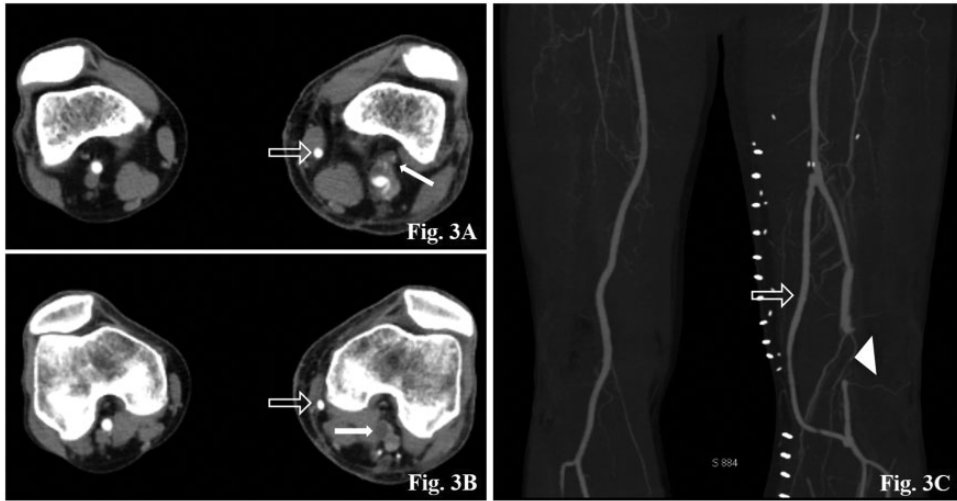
Computed tomography angiography (CTA) images of the lower extremity performed at 6 months after bypass surgery using an ipsilateral reversed great saphenous vein graft. Axial images immediately above the knee (a) and at the knee (b) showing the remaining cystic mass compressing the left popliteal artery (white arrows), and the patent great saphenous vein graft (open arrows). Note the cystic mass, which extends along the lateral superior geniculate artery (white arrow in A); and (c) coronal maximal intensive projection image showing the patent great saphenous vein graft (open arrow) and short-segment non-opacification of the left popliteal artery again (white arrowhead).
